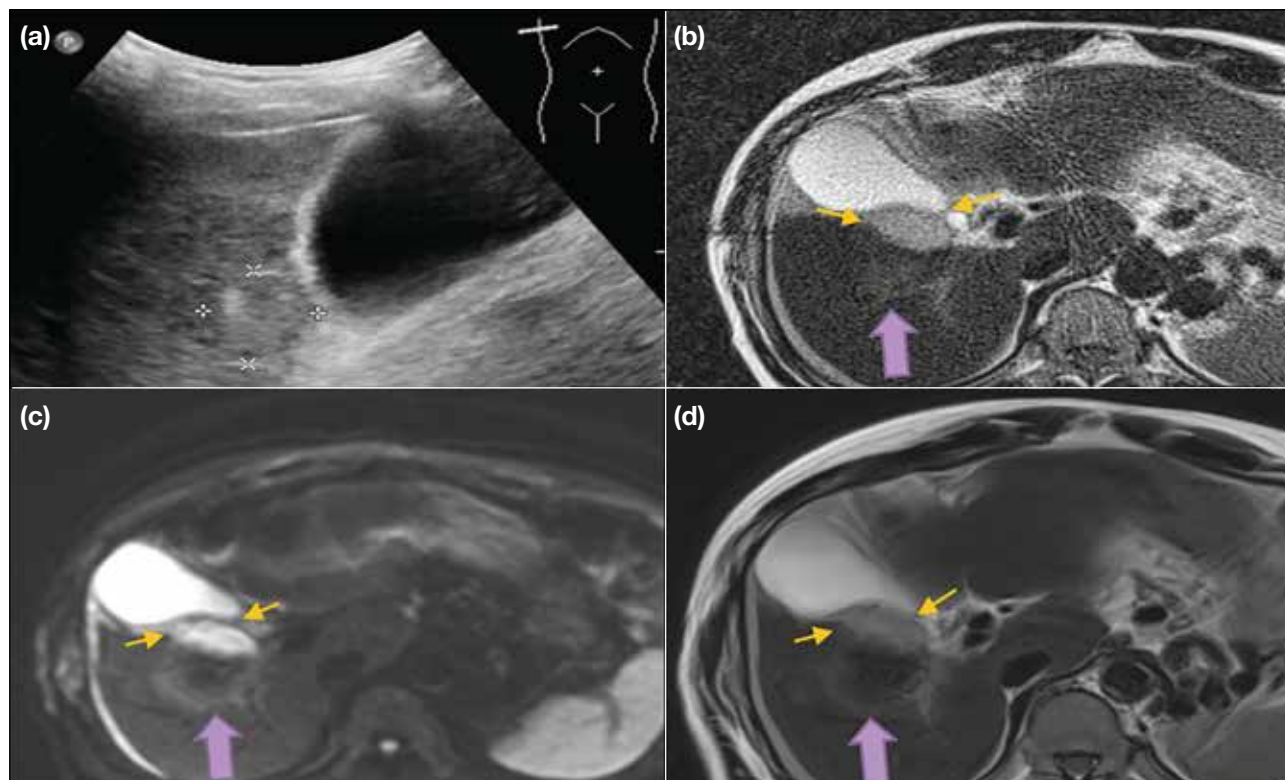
(a) The index lesion is only vaguely seen adjacent to the gallbladder on ultrasound (US). The operator elected to perform magnetic resonance-guided ablation. Under US guidance, the targeted pericholecystic area is punctured with a 16-gauge angiocatheter needle. (b-d) 30-mL 5% dextrose solution is instilled. T2-weighted BLADE, diffusion-weighted and T1-weighted images showing a water cushion (arrows) dissecting the gallbladder away from the target lesion (thick arrows).
